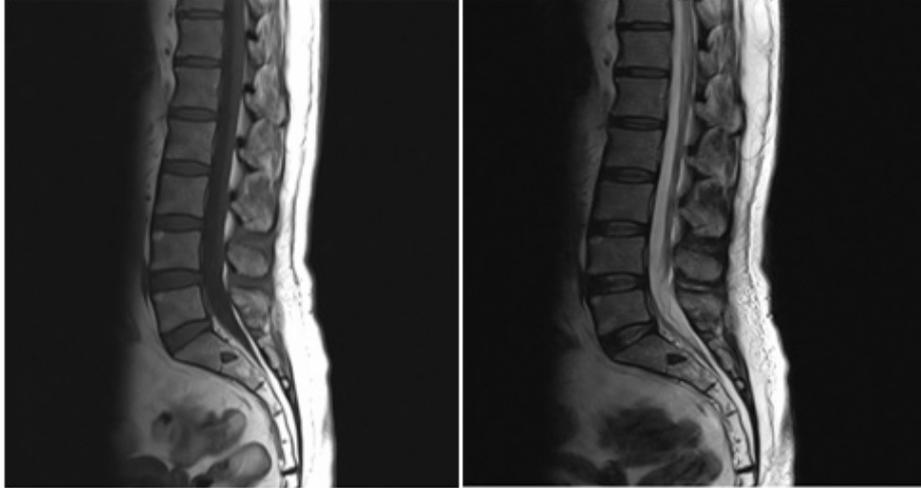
There is no pathology on T2 weight lumbosacral MRI
